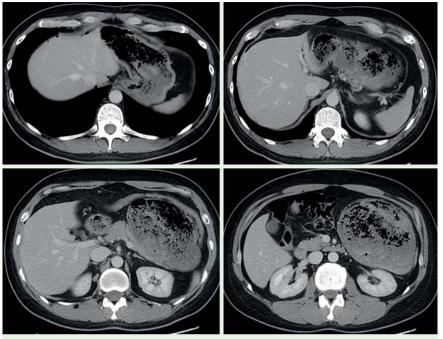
Admission abdominal computed tomographic scan of a 42-year-old man with a 3-day history of epigastric pain and tarry stools.
